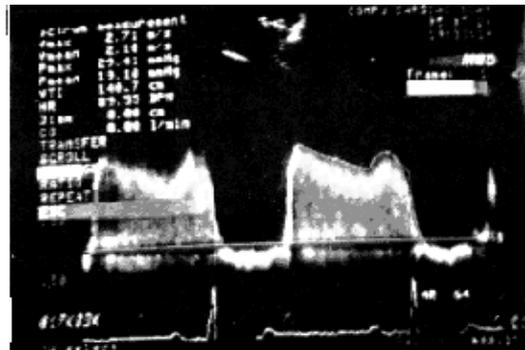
Showing the standard CFFT spectrogram for Doppler signal from a patient with stenosed mitral valve.
